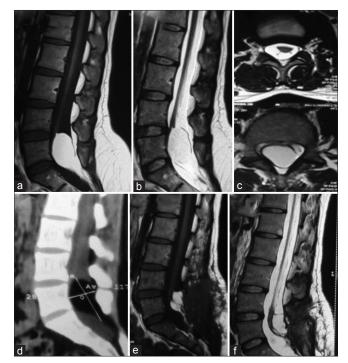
(a) T1 hyperintense (b) T2 hyperintense lobular mass in the conus region with extension along the filum (c) with tethering of the cord suggestive of transitional lipoma. A subcutaneous lipoma is also seen. On computed tomography, the mass is hypodense, no posterior element deficit is seen (d). Postoperative scan shows small residual fat along filum with detethering of the cord (e and f)
